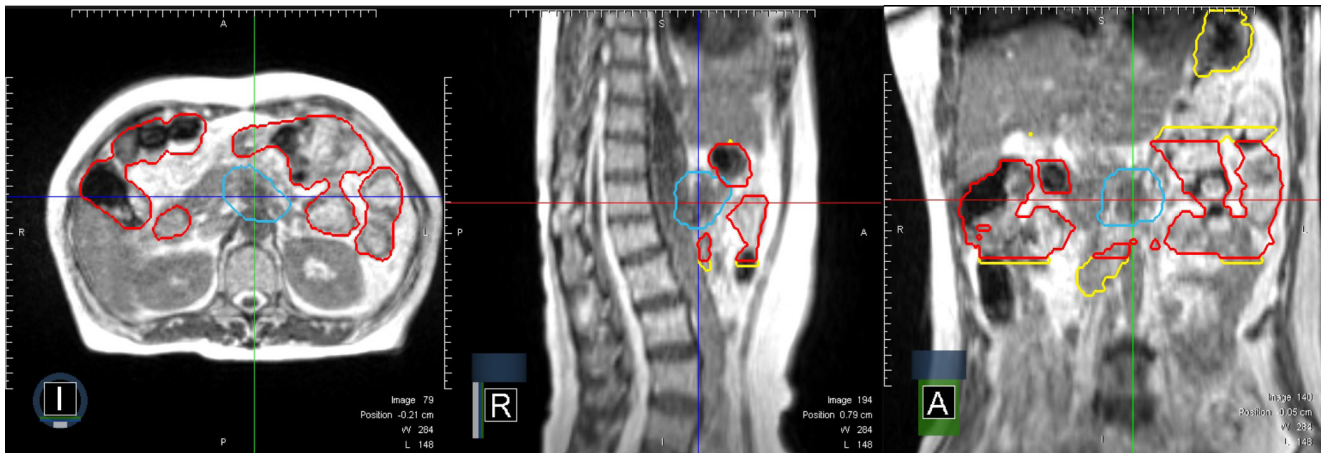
MR image of OAR contours according to methods of re-contouring of one treatment fraction, with PTV (light blue) and the contours of Rough OAR (red) and Full OAR (yellow). MR, magnetic resonance; OAR, organ-at-risk; PTV, planning target volume.
